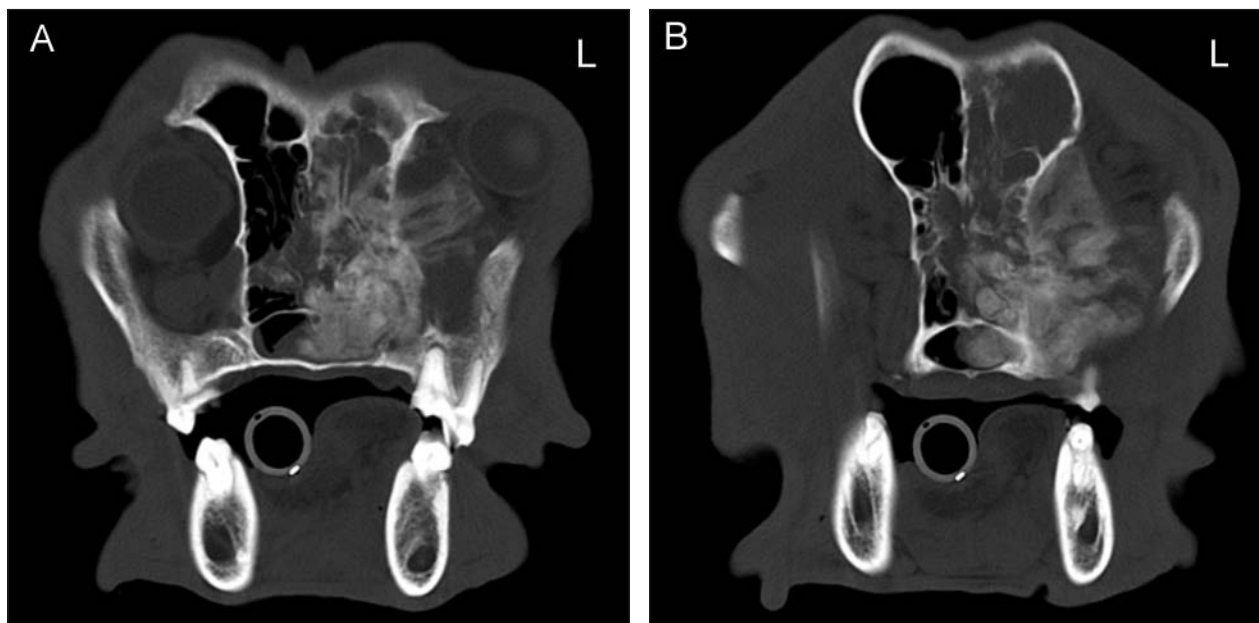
Transverse precontrast computed tomographic image (slice thickness, 5 mm) obtained at the level of the maxillary first molar (A) and cribriform plate (B) in a 9-year-old sexually intact male Rottweiler with a 1-month history of unilateral, left epistaxis. Images were acquired by use of a sharp algorithm and are displayed in a bone window. L = Left.
